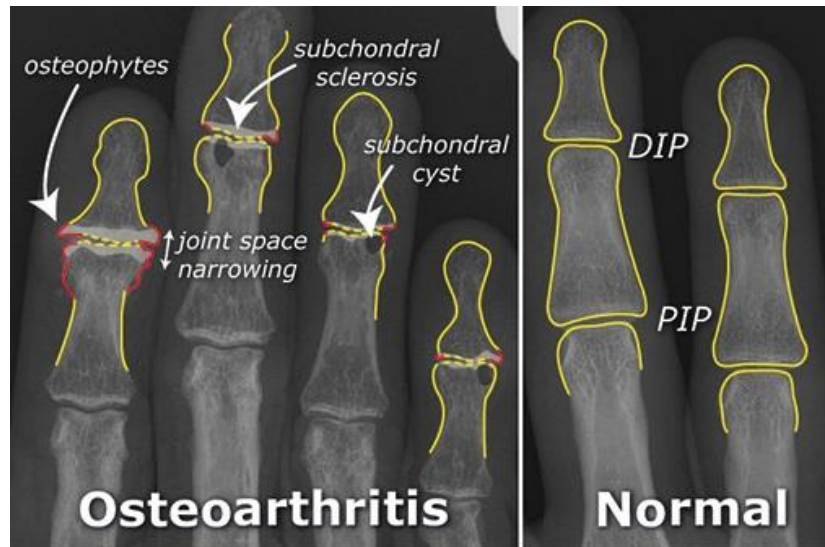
X-Ray of OA hand showing typical features [181]
